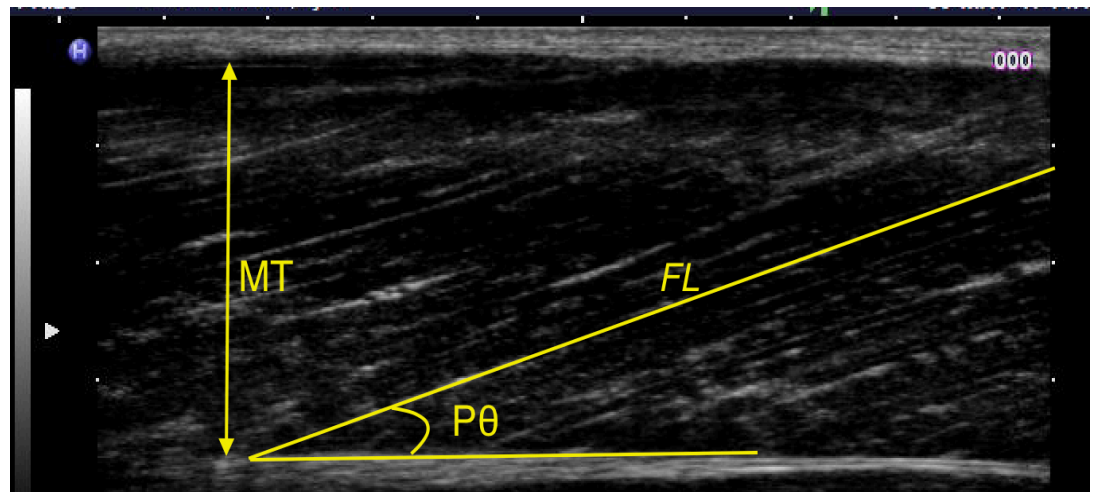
An example of B-mode ultrasound to measure muscle architecture of vastus lateralis: Pennation angle ($P\theta$), fascicle length (FL) and muscle thickness (MT). Fascicle lengths may need to be extrapolated. Image taken from Study 4
